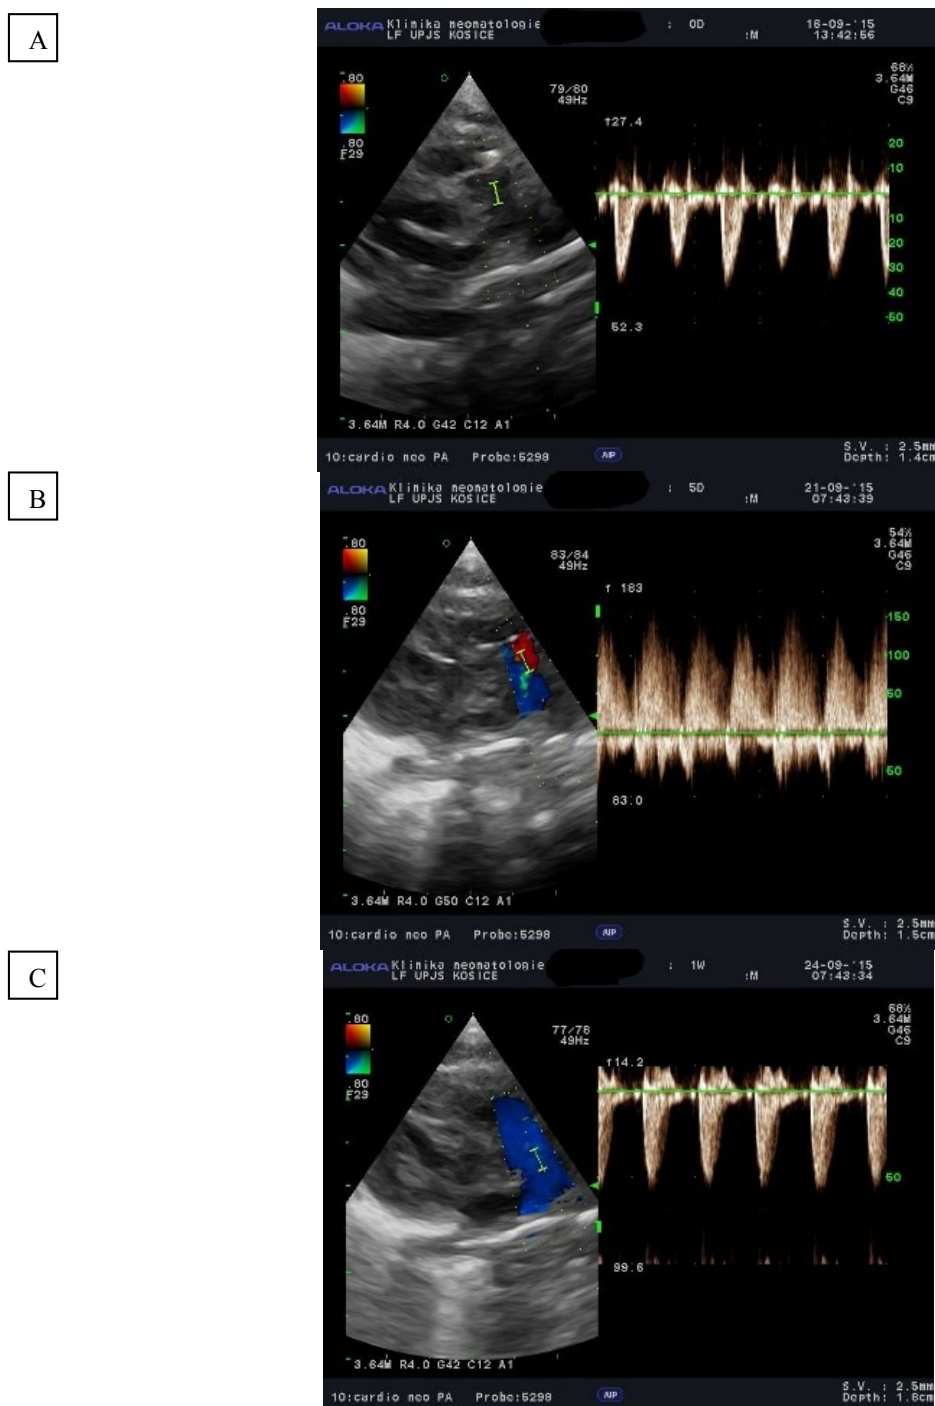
Doppler flow measurements in the pulmonary artery of the ELBWN. *Soon after delivery (A) , signs of ductus arteriosus persistent in age of 5 days (B) and three days later after the treatment with ibuprofen (C).*
